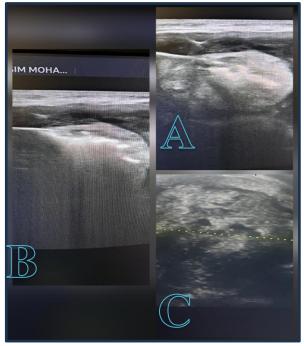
A patient with large left lobe thyroid nodule =25ml underwent radiofrequency ablation underwent under the ultrasound guide. A) early in ablation session, B) near the end of session, and C) 3 months after ablation showing decreasing size to 4ml and decreasing echogensity.
